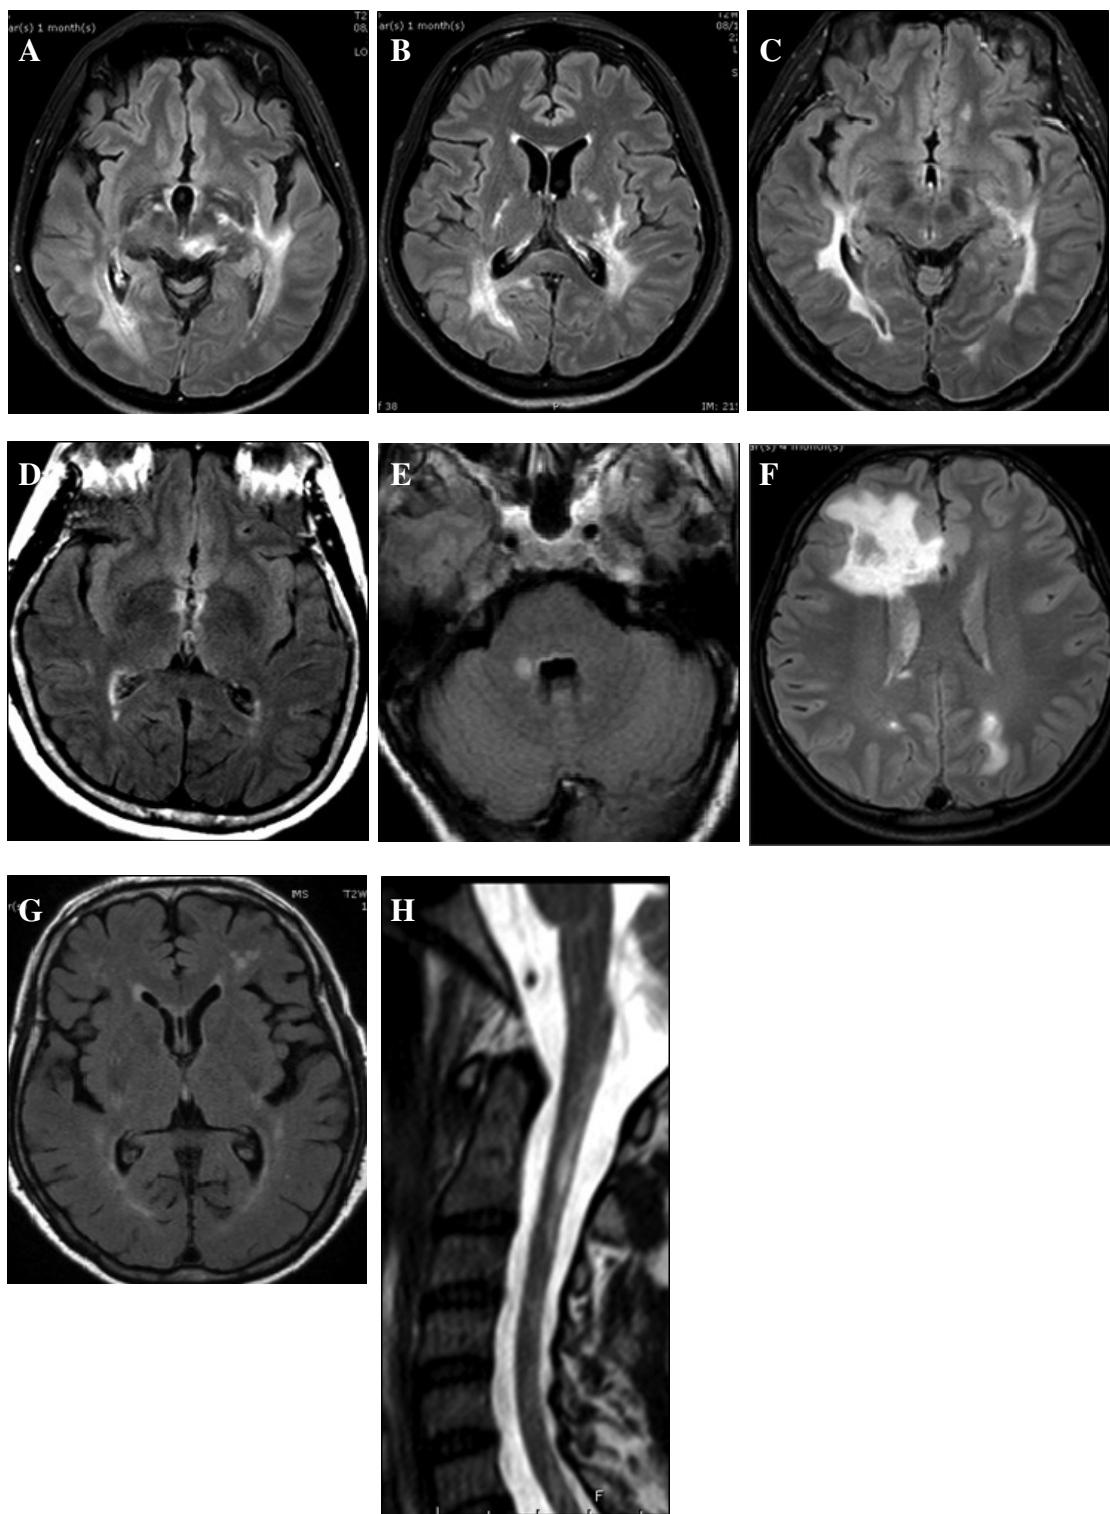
Brain MRI findings classified according to Kim *et al.*²⁶ (A, B): corticospinal tract, (C): subependymal lateral ventricle, (D, E): subependymal 3rd/4th ventricle, (F): extensive WM lesion, (G): nonspecific pattern, (H): medulla extending to cervical cord
